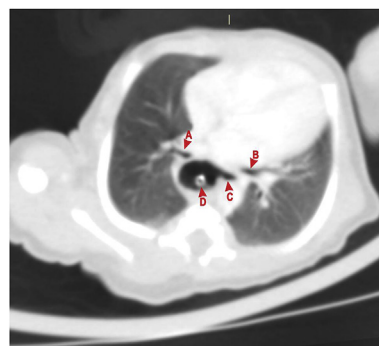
CT scan performed on the patient from case #2 showing LV type IVb. (A) Right mainstem bronchus (B) Left upper lobar bronchus (C) Left lower lobar bronchus (D) Nasogastric tube in common trachea-esophageal cavity.
